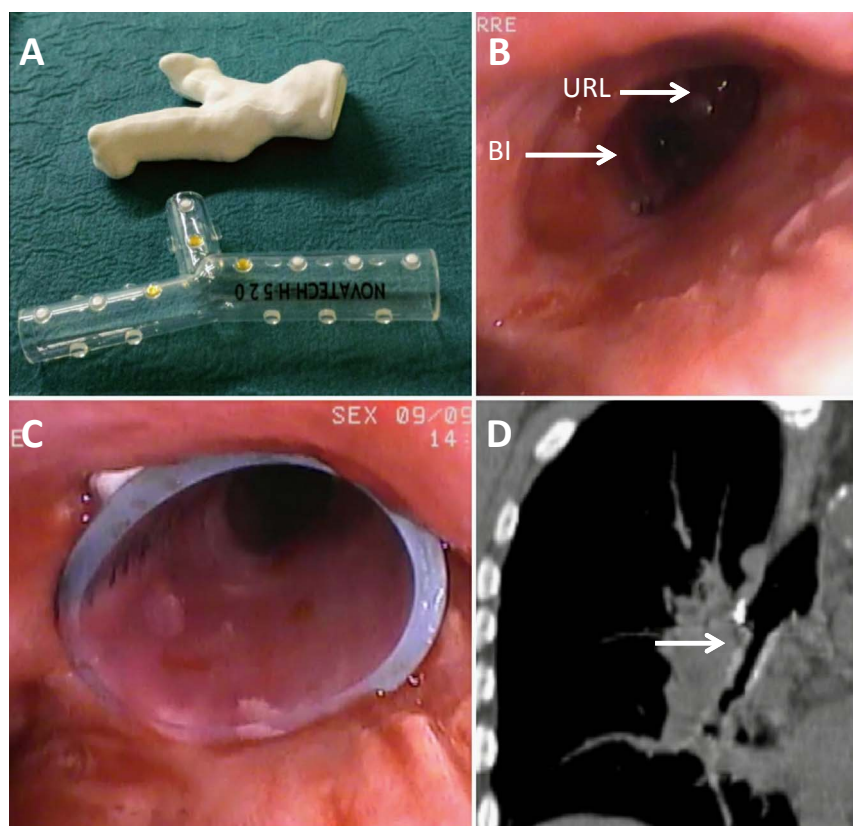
1A: 3D-printed model of right main bronchus (Builder premium medium) after virtual correction of the obstruction (VGStudioMax 3.0, Volume Graphics GmbH), allowing for the customization of an Oki Stent (Novatech); 1B: Bronchoscopic view of the right main bronchi after mechanical debulking of the intraluminal obstruction and dilatation 1C: Bronchoscopic view after stent insertion under rigid bronchoscopy, showing good accuracy of the modified stent; 1D: Sagittal CT-scan view after stenting, showing good congruence of the modified stent with the right main bronchus, right upper lobe and bronchus intermedius. URL: upper right lobe; BI: bronchus intermedius.
